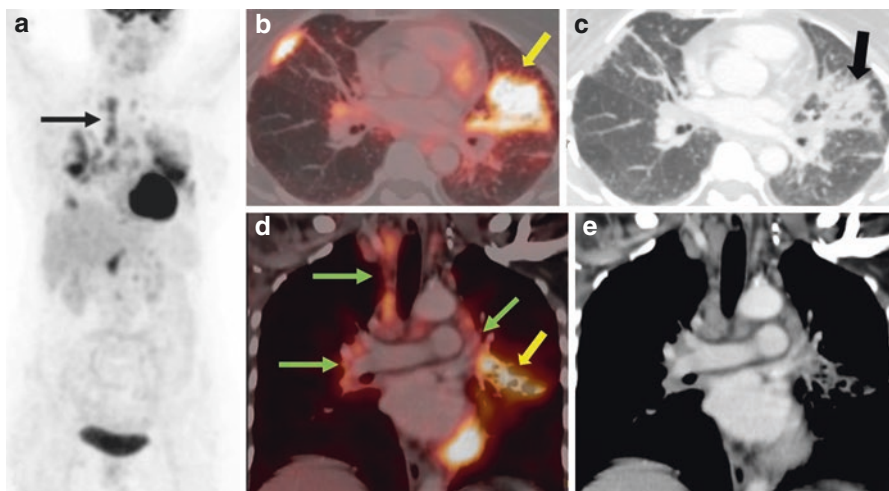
MIP, axial, and coronal images of whole-body PET/CT scan of a 43-year-old lady who had been treated for carcinoma right breast and was being evaluated for suspected recurrence. The images show hypermetabolic enlarged bilateral hilar and paratracheal nodes with FDG-avid interstitial thickening and nodular opacities predominantly in the left lung (a-e). Biopsy confirmed sarcoidosis
